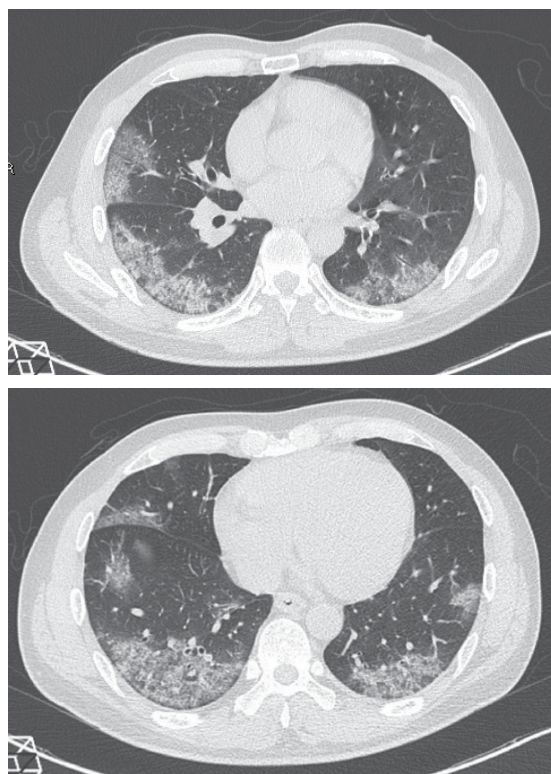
Axial chest HRCT scans showing multifocal and bilateral ground-glass opacities, with peripheral and posterior predominance, which are typical pulmonary findings of COVID-19 infection (confirmed by RT-PCR).
